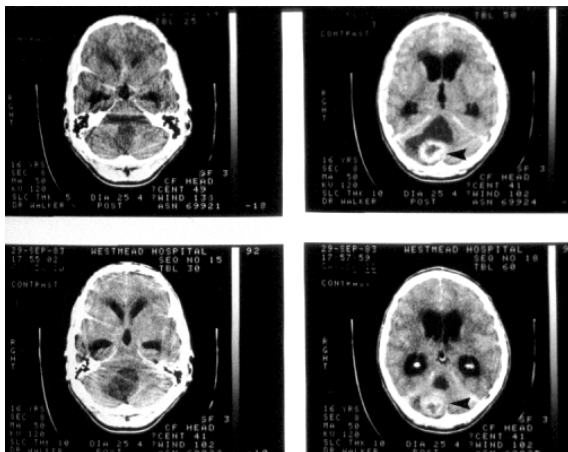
A series of enhanced axial CT scans through the posterior fossa show a doughnut shaped enhancing mass within a partly-cystic lesion (arrowheads) located in the midline of the cerebellar vermis. Obstructive hydrocephalus is evident. At surgery, a low grade part cystic and part-solid astrocytoma was confirmed.
